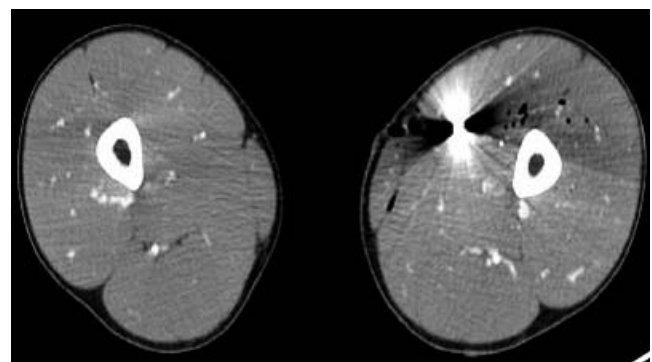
Axial computed tomography angiography image shows arterial anatomy in the mid thigh with a bullet in the left medial thigh at the normal anatomic position of the femoral artery.
